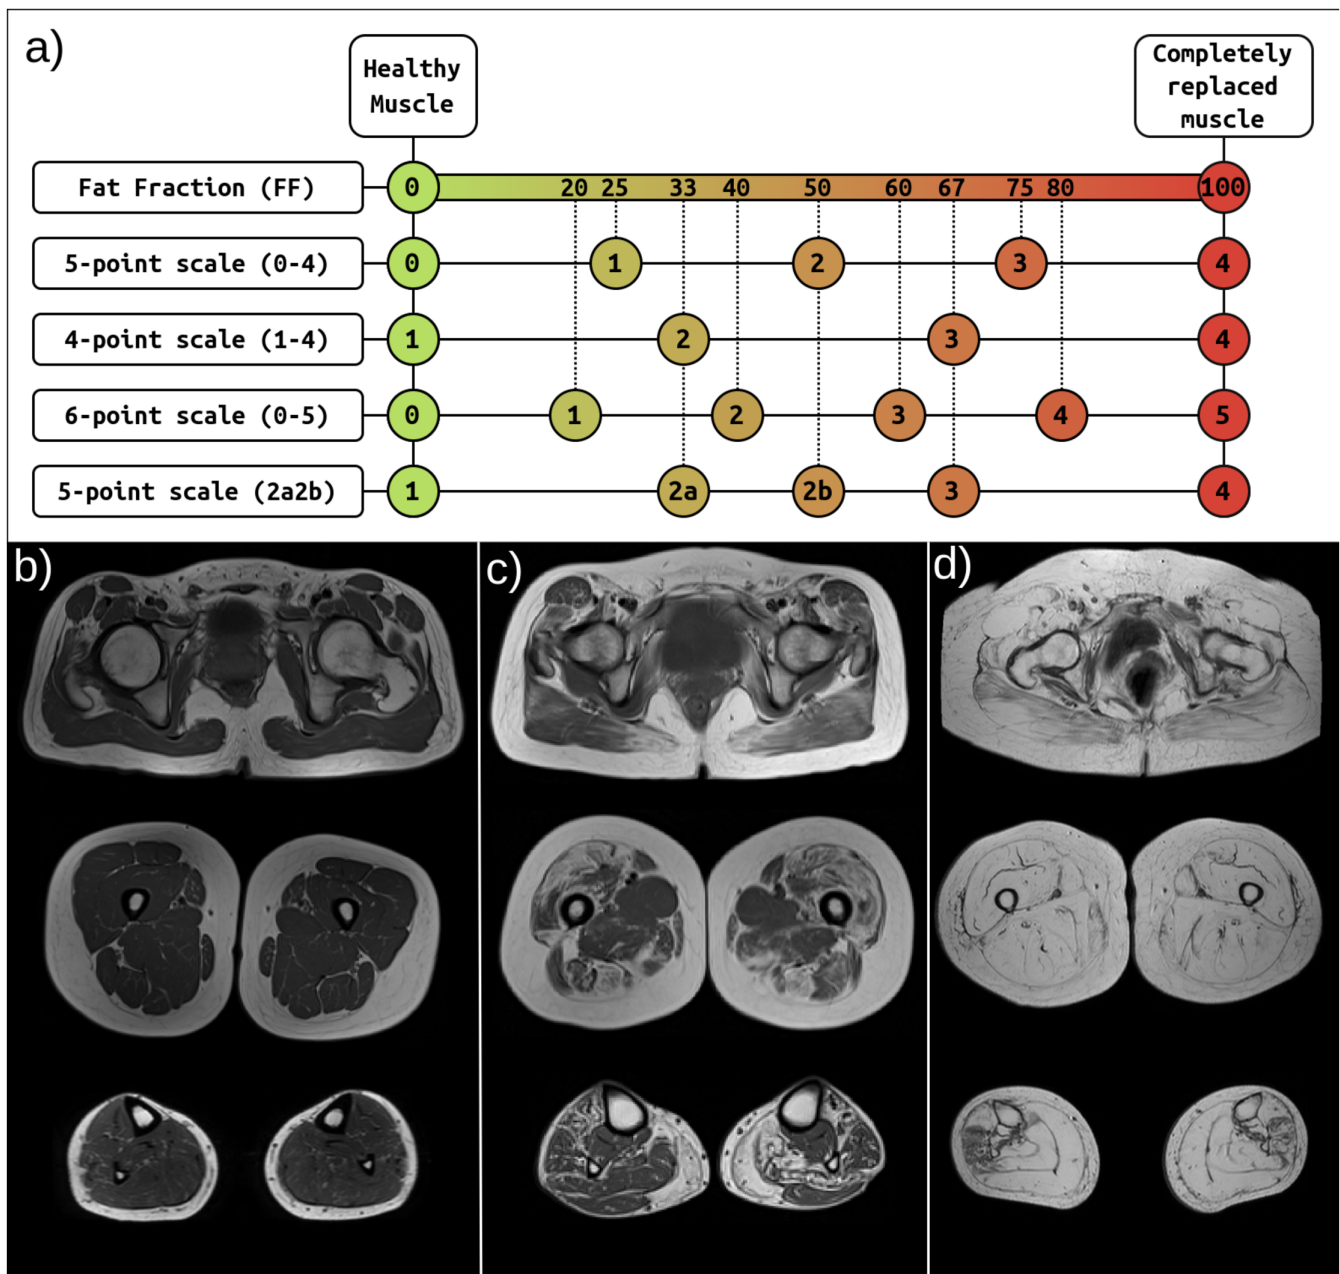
(a) Representation of the different muscle fat scales found in the dataset. Each row represents a different scale, and each coloured circle represents a possible value. The fat fraction scale is continuous, and the rest are discrete. Discrete scales are projected over the FF scale to show differences in muscle fat quantisation. (b) MRI examples of healthy muscle, (c) intermediate-stage muscle and (d) late-stage muscle. Fatty tissue appears with high intensity in the MRIs (white/light grey), whereas muscle tissue appears with low intensity (dark grey). The top row of the MRIs represents a pelvis/waist-level axial slice, the second row represents a thigh axial slice, and the last row represents a calf axial slice.
